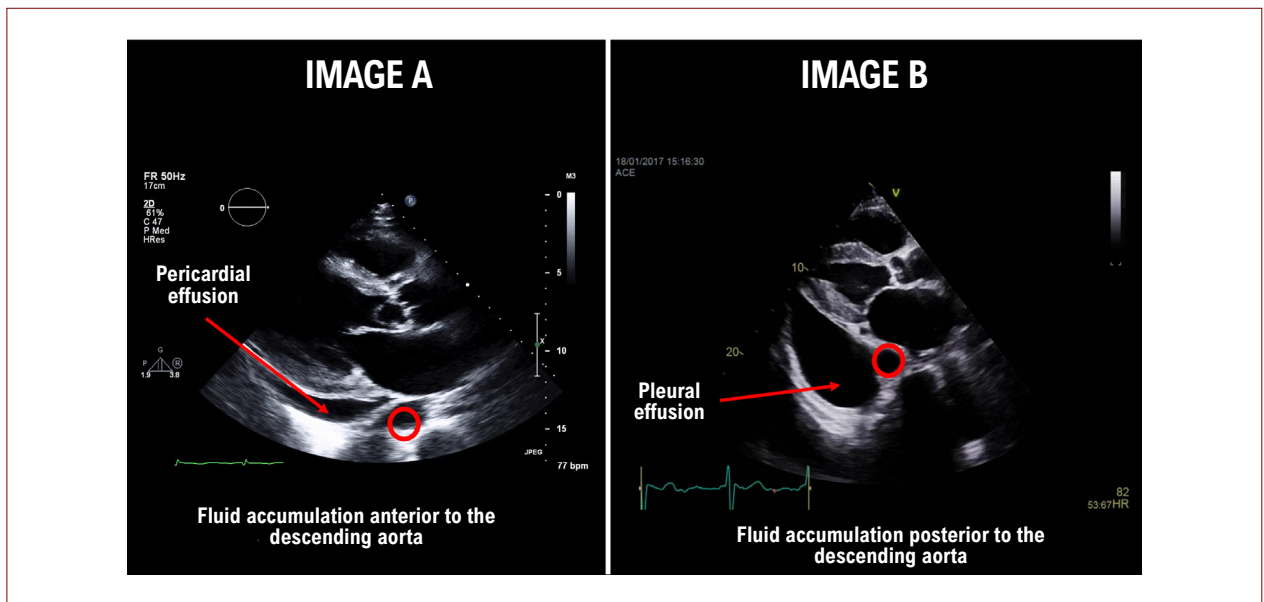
Echocardiographic differences between pericardial effusion (Image A) and pleural effusion (Image B), using the descending thoracic aorta as an anatomical reference parameter.
